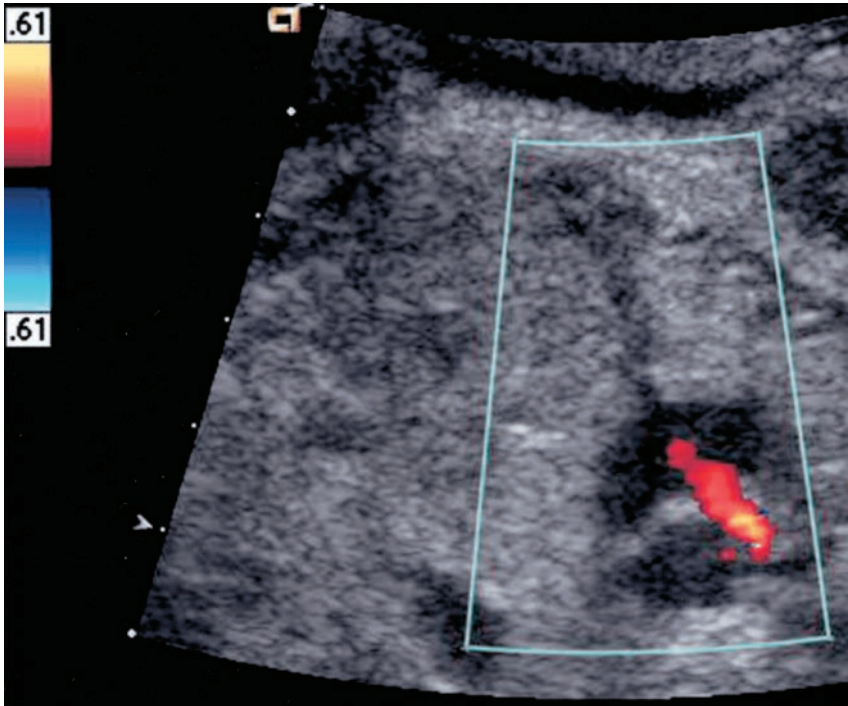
Ultrasound image with color Doppler showing transseptal flow through newly created 2.5-mm atrial septal defect.
